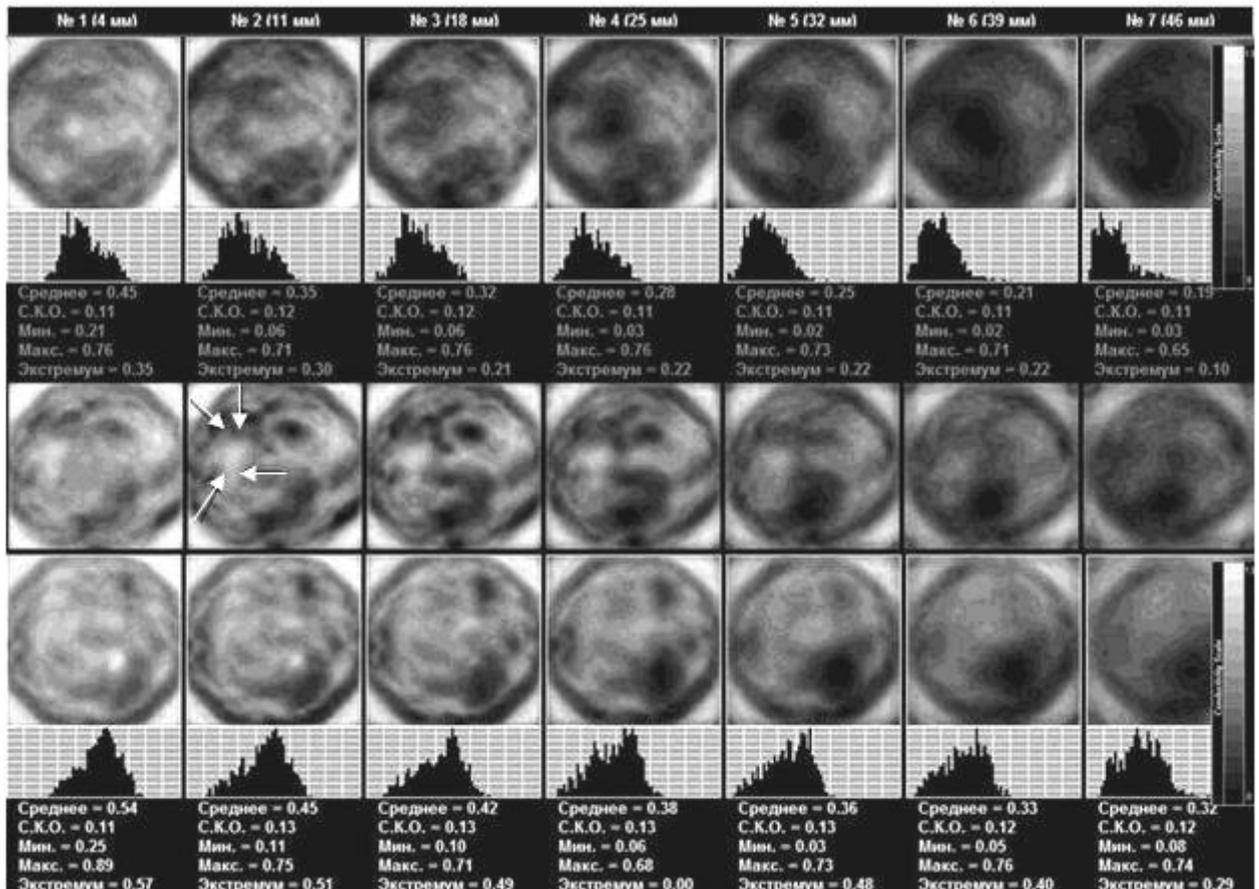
EIM. Top row – left gland. Fibrous type of mammary gland structure. Hyper-impedance contour and background. The middle row represents the upper-outer segment of the left gland. At 9 o'clock position there is an irregular-shaped iso-impedance formation measuring 34x27 mm with a hyper-impedance contour. Lower row – right gland. Mixed type of mammary gland structure. ULTRASOUND: A 23x44x33 mm formation with blurred irregular-shaped contours is located in the boundary of upper-outer and lower segments of the left mammary gland.
